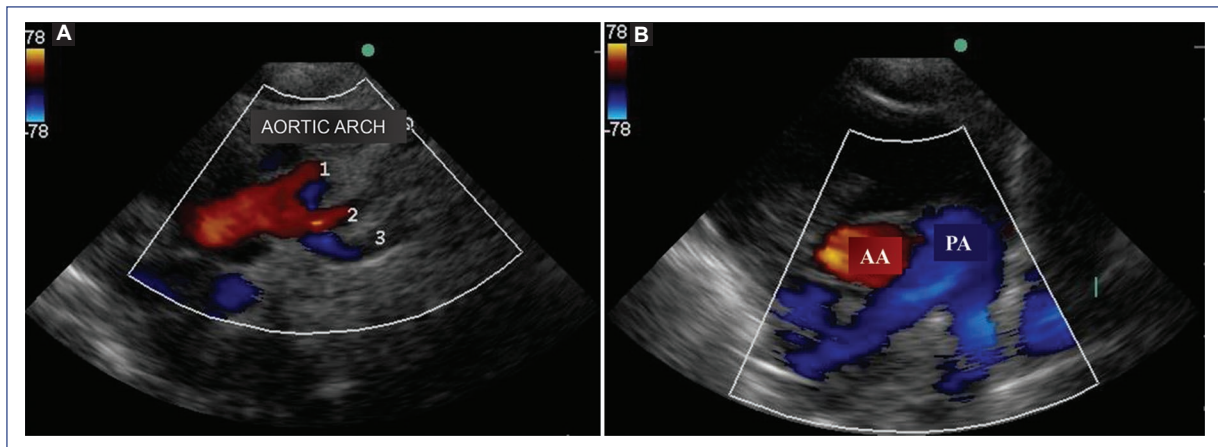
Echocardiogram. A: the aortic arch and three supra-aortic vessels with no continuity with the descending aorta are observed. B: pulmonary artery (PA), ascending aorta (AA), and confluent branches are shown. Absence of *ductus arteriosus*.
